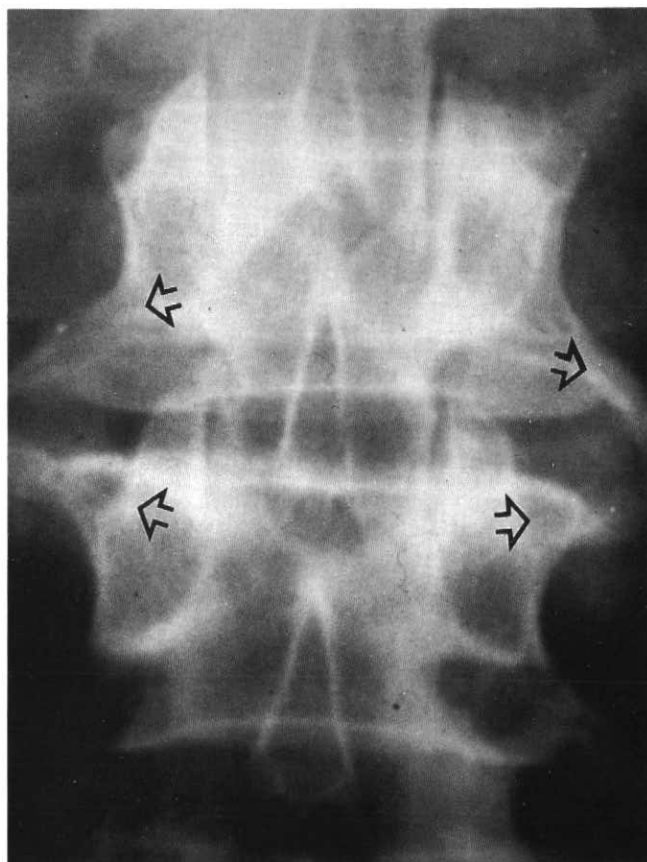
Anterior-posterior x-ray view of human spine. Osteophytic spurs (open arrows) identify presence of *spondylosis deformans*.
